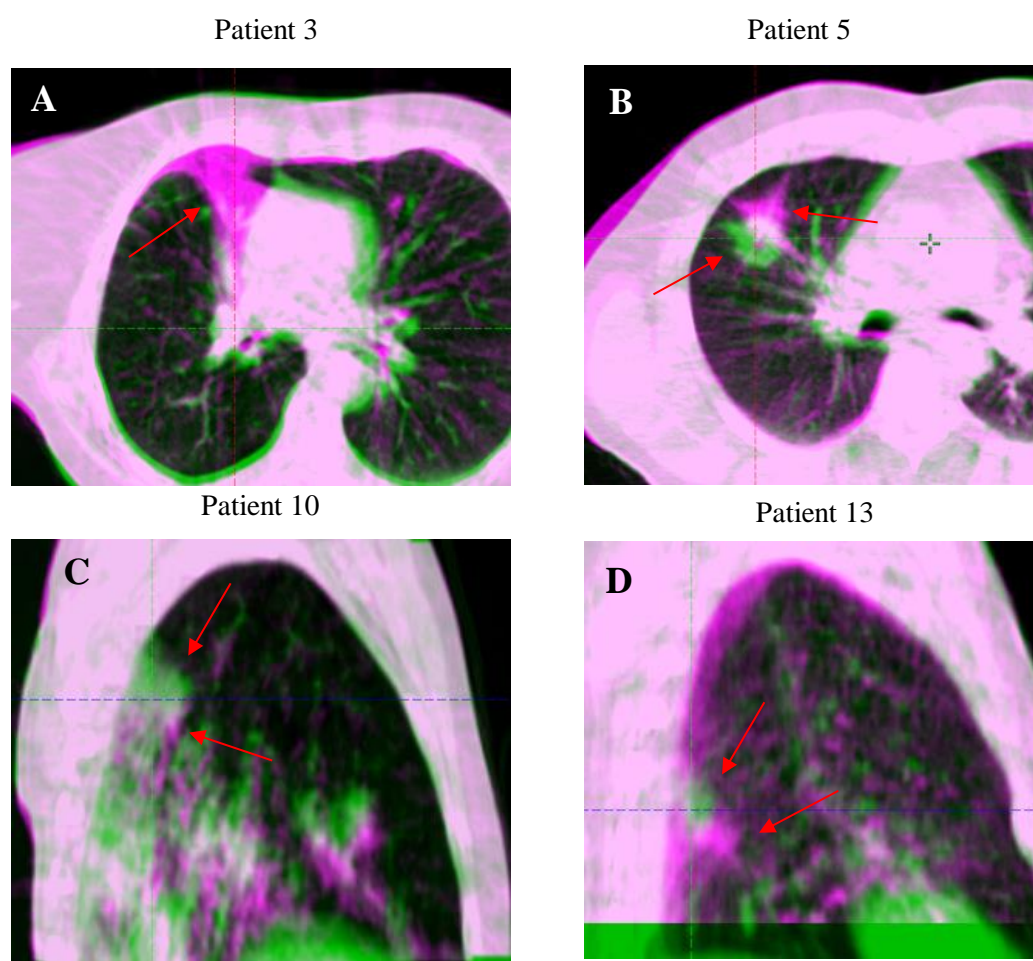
(A) Patient 3 with re-appearance of atelectasis on the first CBCT post-rCT, (B-D) tumor positional deviation on CBCT post-rCT for patients 5,10 and 13. In patients 10 and 13 the tumor shift was in the caudal direction for the CBCT. The image registration between CBCT and rCT (B-D) was according to bone ([50; 3000] HU) to highlight the tumor shift. (A-B) Images are in the transversal view and (C-D) in the sagittal view, with lung window level. In the blended images, rCT images are green, and CBCT is magenta; the red arrows highlight the anatomical change between rCT and CBCT.
